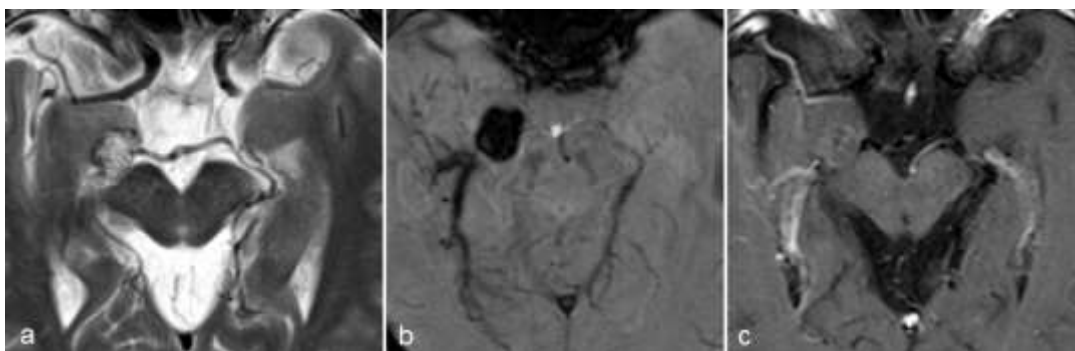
Axial T2-weighted (a), susceptibility-weighted and contrast-enhanced T1-weighted images reveal a cavernoma in the right uncus.
